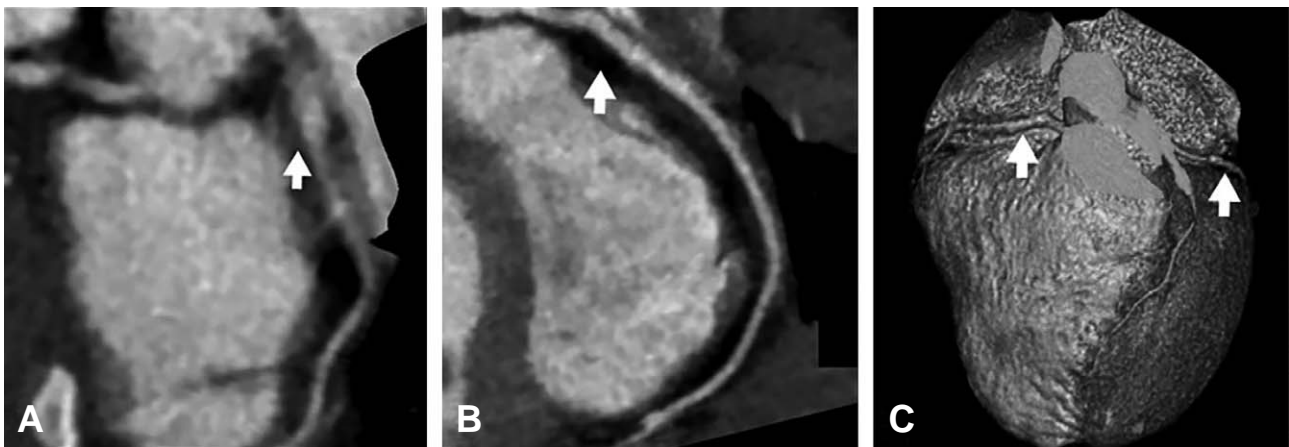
The 29-month follow-up cardiac computed tomography findings (January 2020). It shows the improved left main and ascending coronary arterial ectasia (arrow; length, 11 mm; diameter, 4.7 mm; Z-score = 4.0) with mild residual dilatation and focal dilatation of the left circumflex artery (diameter, 4.2 mm) (A) and a right coronary arterial ectasia (arrow; diameter, 4.3 mm; Z-score = 2.9) with minimal residual coronary dilatation (B). These findings are also seen in a 3-dimensional reconstruction image (arrows; C).
